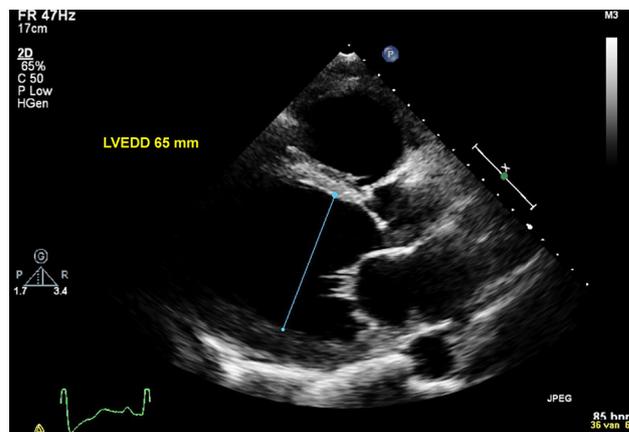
Echocardiogram with dilated left ventricle at investigation following first cardiac symptoms. LVEDD, left ventricular end-diastolic dimension.
